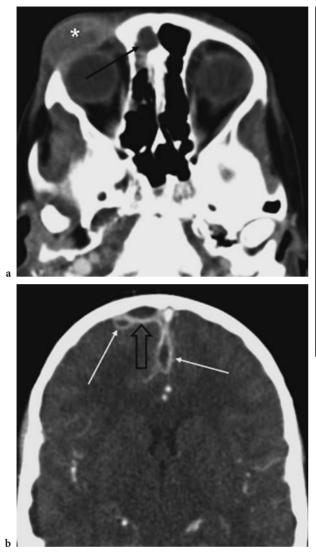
A 10-year old boy with acute sinusitis develops peri-orbital swelling (cellulitis) and epilepsy. a Axial 5 mm image of standard-dose CT with intravenous iodine contrast with 120 kV and 125 mAs (CTDI_{vol} of 24 mGy) shows right-sided frontal sinusitis (*black arrow*) and orbital cellulitis (*asterisk*). b There is intracranial extension with epidural (*open black arrow*) and subdural empyema collections (*white arrows*), which is confirmed on a 5 mm sagittal MPR image (c). Calculated effective dose of the CT exam was 1.4 mSv
